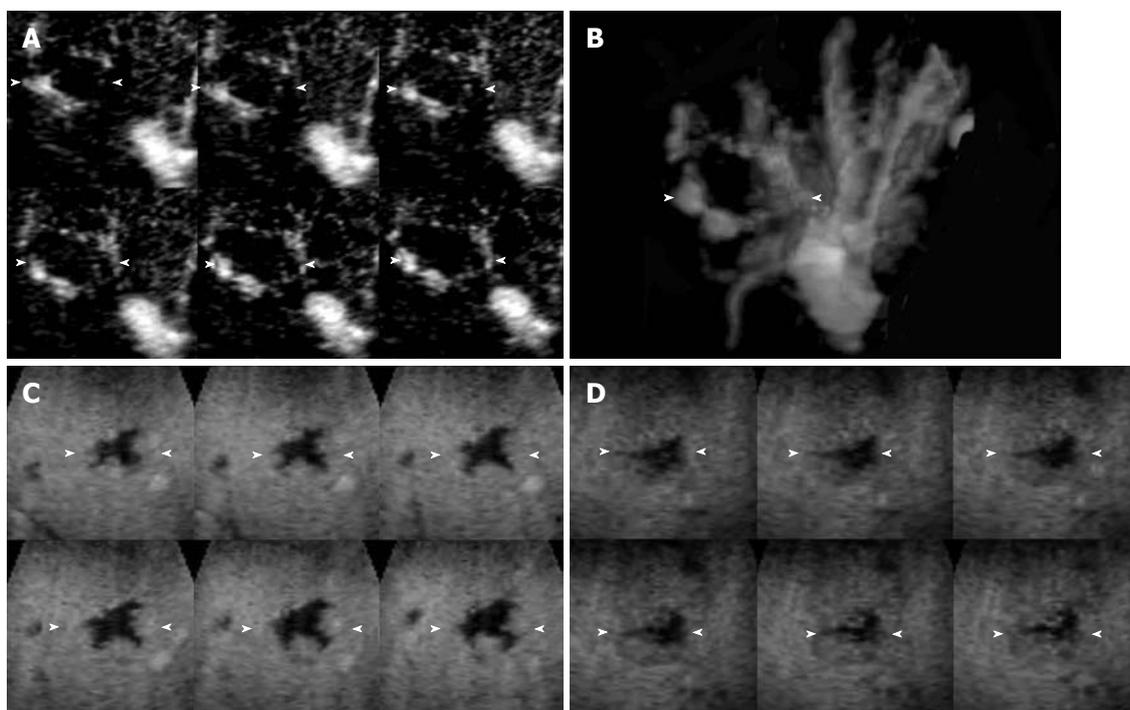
CE 3D US images of the liver in a 59-year-old woman with a hemangioma in the anterior inferior segment of the right lobe. A, B: Tomographic ultrasound image in plane A with slice distance 1.0 mm (A) and sonographic angiogram rendered by average intensity with surface mode (B) show peripheral nodular enhancement without distinct tumor vessels in the early phase; C: Tomographic ultrasound image in plane B with slice distance 1.0 mm shows peripheral nodular enhancement in the middle phase; D: Tomographic ultrasound image with slice distance 1.0 mm in plane B with slice distance 1.0 mm shows hypoechoic pattern in the late phase. Persistent enhancement over time was detected in this lesion. Arrowheads indicate the tumor margin.
